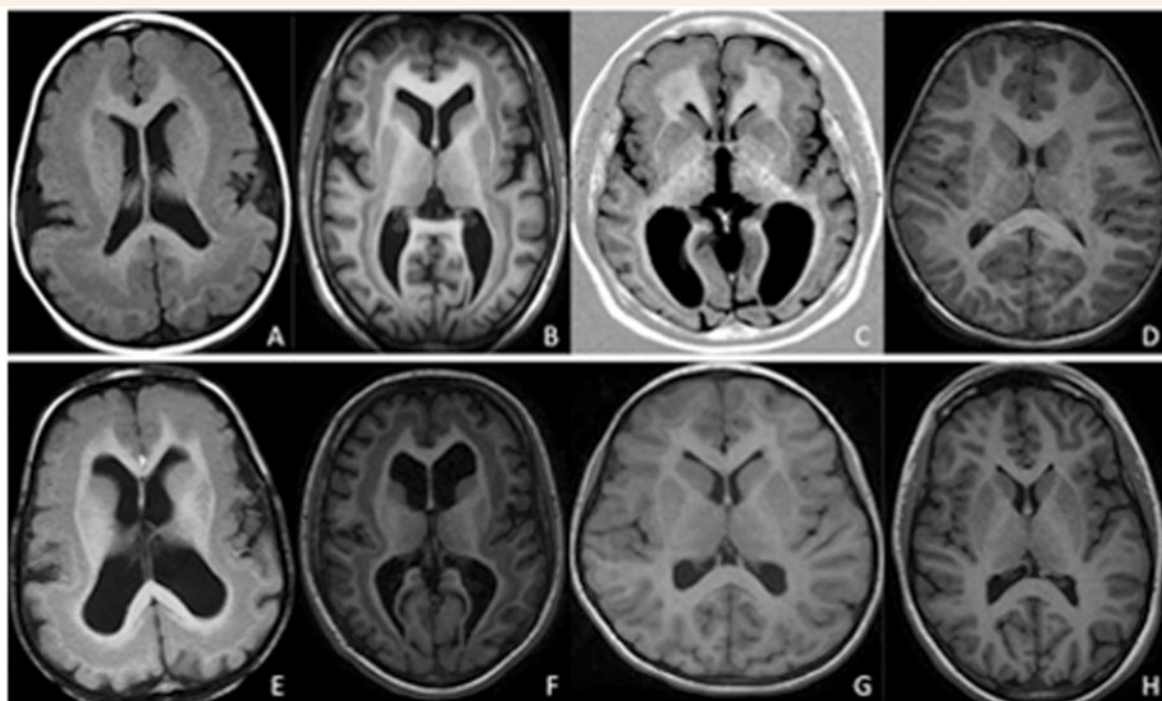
Variable extent and thickness of band in cases with sporadic SBH. Representative MRI scans in patients with either a thick continuous band around the entire brain (grade 3–4) (A, B, E and F) or a thinner band only present in the frontal lobe (G) or restricted to the frontal and temporal lobe with intermediate thickness (grade 2) (C). Thick and continuous band around the entire brain in two patients aged 2 years and 11 months (A) and 3 years and 6 months (E), respectively. The bands appear to fuse with the outer cortex in the frontal regions. Intermediate diffuse SBH in two patients aged 15 (B) and 16 years (F). Thin band only present in the frontal lobe (G) or restricted to the frontal and the temporal lobe (C) in two patients aged 24 years and 11 years. D and H are from control patients aged 3 and 15 years, respectively.
